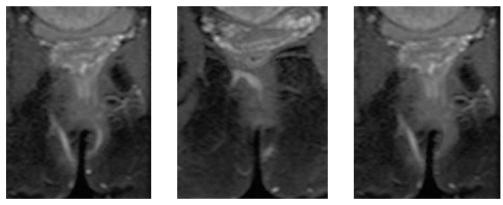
A case of suprasphincteric fistula. Coronal STIR sequence MR imaging, two fistula tracts were detected in the ischeoanal region. On the RT side, the fistula tract runs over the puborectalis muscle which persists after the fibrin glue treatment.
